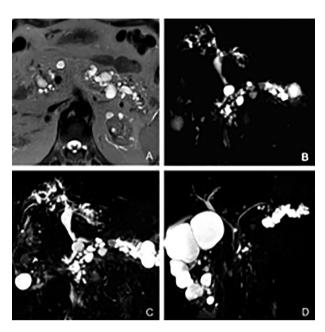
Combined IPMN. Axial T2-weighted image (A), MRCP (B) and MIP (C) images in a 83 years-old male patient. MIP (D) image (different patient from A, B case) shows a combined IPMN with segmental dilation of MPD localized in pancreatic head
